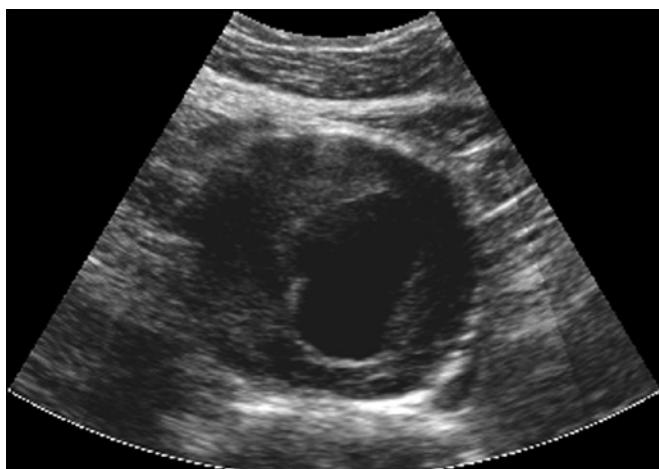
Ultrasound image of an abdominal aortic aneurysm. Note the presence of a large thrombus inside the aneurysm sac.
